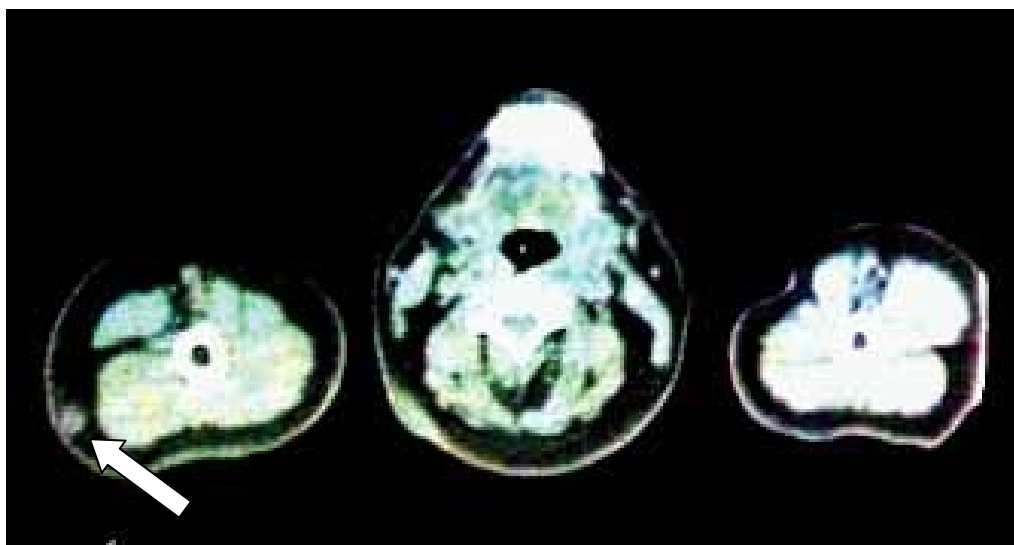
Corresponding CT image shows a lesion at the superior posterior aspect of the right arm. (Arrow)
